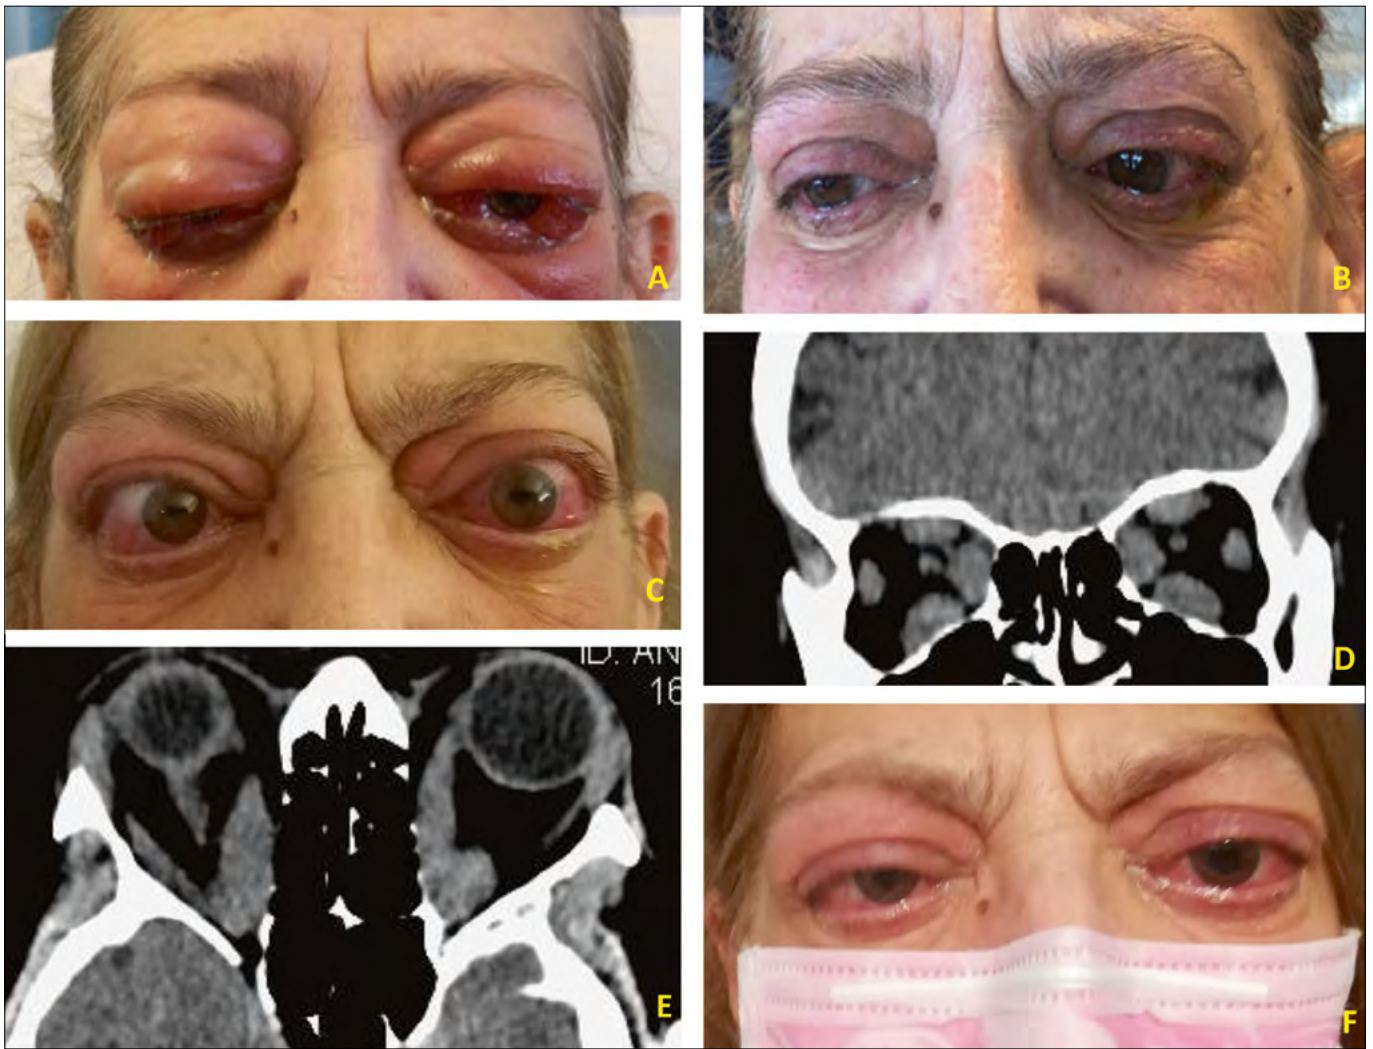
63-year-old female patient, smoker, affected by active, sight-threatening GO, treated with administration of 1 g of intravenous methylprednisolone for three consecutive days. (A) Patient before therapy. (B) Two weeks after therapy. After thyroidectomy, a better control of hormonal levels was achieved. (C) Two months later, her visual acuity worsens to right eye: 4/20 left eye: 3/20 with anomalous colour vision test (dysthyroid optic neuropathy). (D-E) On CT-scans images, all the EOMs are enlarged with apex crowding. (F) After endoscopic bilateral endonasal optic nerve and medial wall decompression the visual acuity has greatly improved, and a 4 mm of proptosis reduction.
